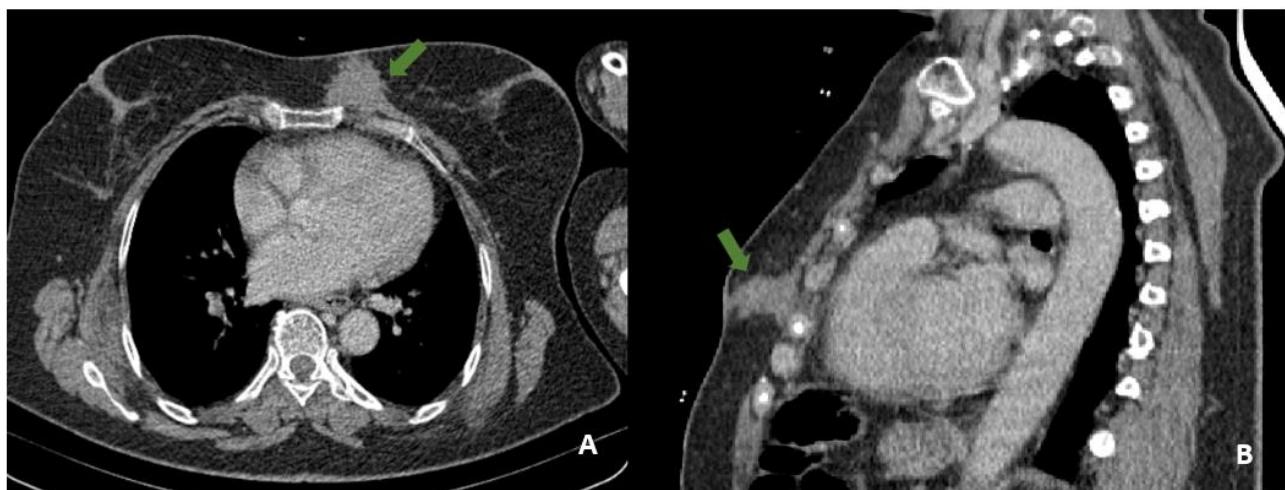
Axial [A] and sagittal [B] images of a chest CT, revealing tissue infiltration in the inner quadrant of the left breast, with involvement of the thoracic wall [green arrow]
